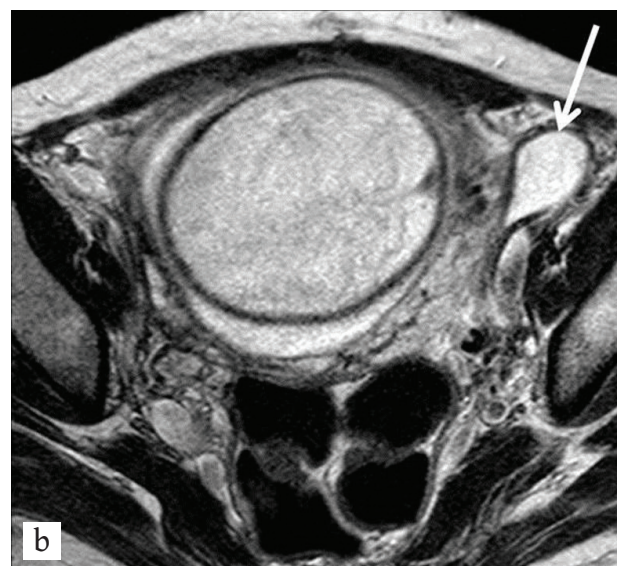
Axial T2W MR images (TR/TE: 3500/90) of a 30-year-old pregnant patient five months after ART. Extensive vaginal wall edema (arrows in a) and a 3 cm lymphocele (arrow in b) are shown
